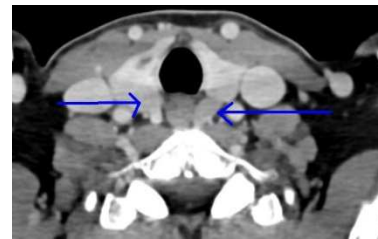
CT scan with contrast injection showing washout of parathyroid nodules at parenchymal time.
